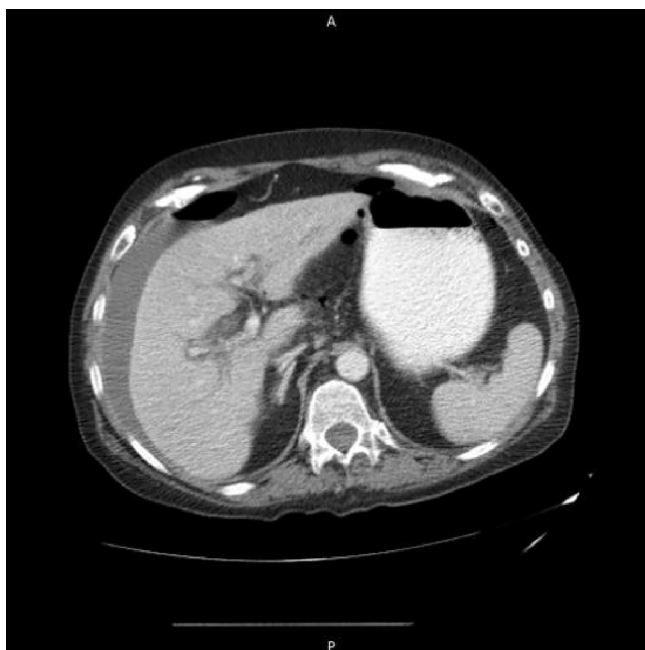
Preoperative axial CT Abdomen showing spleen that was found to be ruptured during laparotomy.
